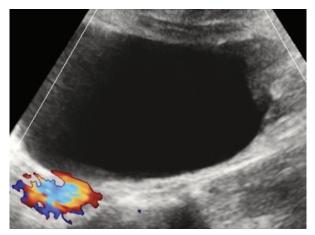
Transabdominal color Doppler image of the same patient as in Figure 18A
